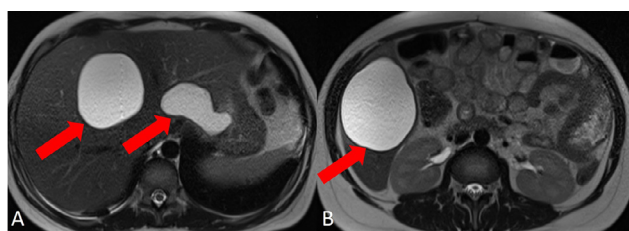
In the unenhanced T2-weighted axial conventional images 2 hyperintense cysts at the right lobe of the liver and 1 hyperintense cyst at the left with hypointense thick-wall.
